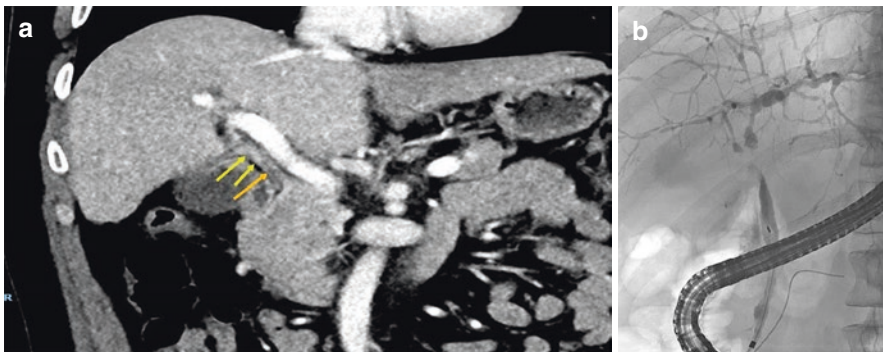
Case 8: Primary sclerosing cholangitis. (a) CT at first presentation (coronal view): thickening and slight enhancement of the common hepatic duct (two yellow arrows). No wall thickening is seen at the common bile duct (orange arrow). (b) ERCP: significant stenosis of the common hepatic duct and cystic duct conjunction extending to the confluence of the left and right main ducts
